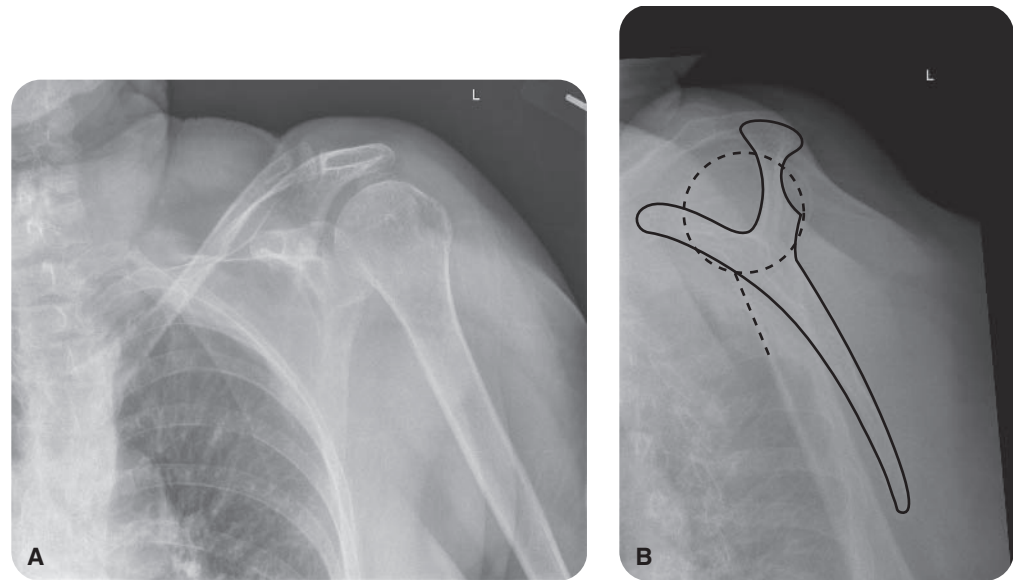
(A and B) Postreduction radiographs of the left shoulder in a more normal alignment.
